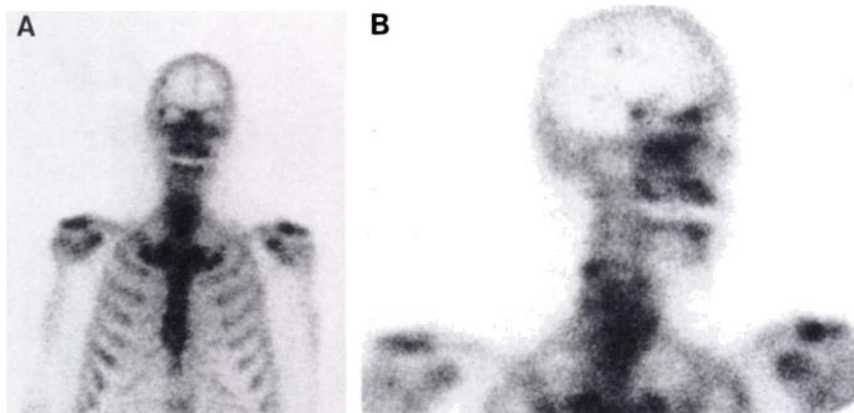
A 60-yr-old patient in whom bone scintigraphy revealed increased uptake in the parietal bone on the anterior (A) as well as the oblique view (B). In addition, there was an abnormality in the 1st lumbar vertebra and left posterior 8th rib. PSA was negative.
